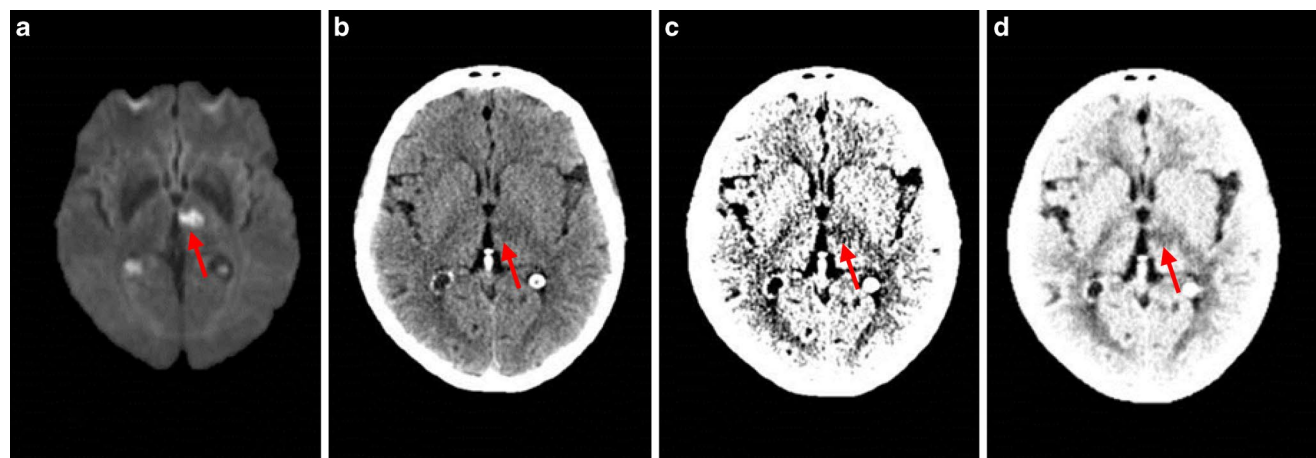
Arrow indicates acute left thalamic LI in DW-MRI (a), NCCT (b), window-optimized NCCT (c) and Best Contrast (BC)
